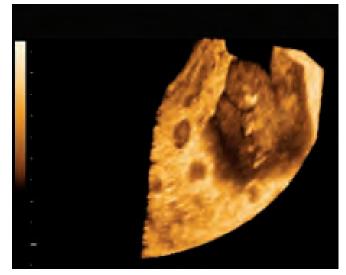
A partial hydatidiform mole was diagnosed by placental molar vesicles and a fetus by the 3D ultrasound *Courtesy:* JR Benitez, Clinics Gutenberg, Spain
